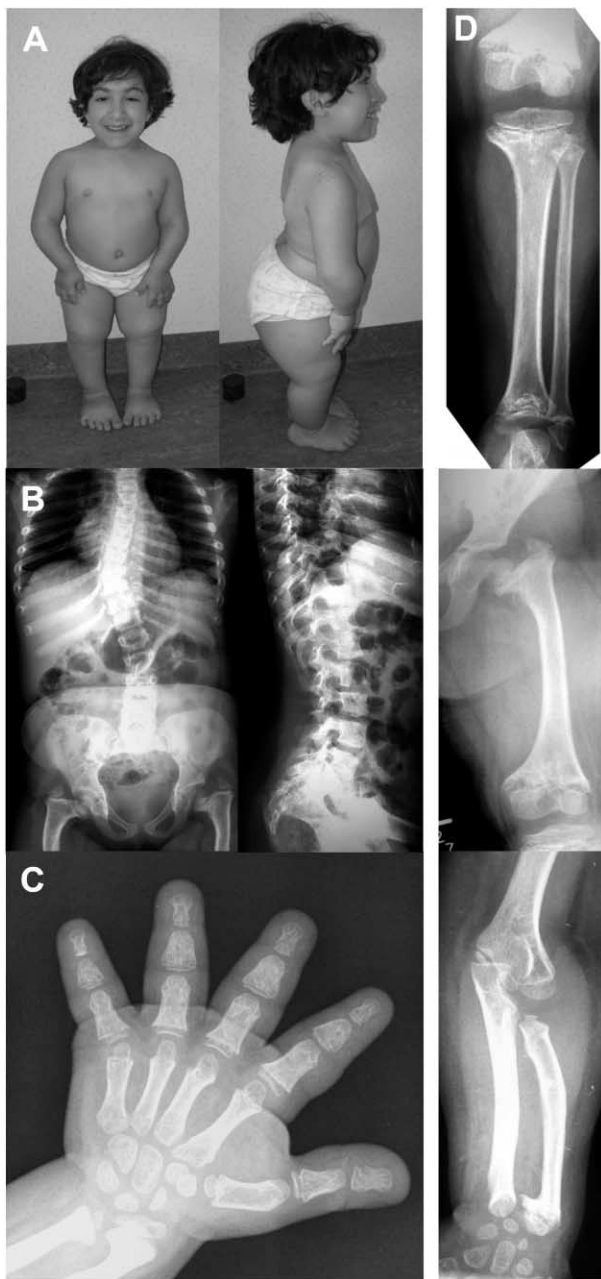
Clinical and radiographic features of the novel patient with the AD phenotype. *A*, Female patient at age 10 years, showing severe disproportionate short stature. *B* and *D*, Radiographs of the axial and appendicular skeleton at age 8 years. The spine is abnormal, with thoracolumbar scoliosis and foreshortened vertebral bodies (on lateral film) showing anterior and posterior scalloping at the lumbar level. The end plates are slightly convex. The pelvis shows coxa vara with dysplastic femoral heads and severe shortening of the femoral necks. The femur, tibia, and fibula are short, with severe metaphyseal changes. The knee epiphyses are small and flattened. There is mesomelic shortening in the upper limbs. *C*, Hand radiograph taken at age 9 years. Metaphyseal changes are apparent in the wrists, with shortening of the distal ulna and ulnar kinking of the distal radius. The phalanges and metacarpals are short and broad (bullet-shaped middle phalanges), with small epiphyses already attached to the metaphyses.
